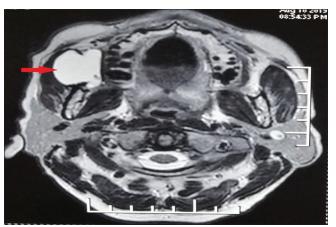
Imaging axial magnetic resonance imaging (T1-weighted imaging): A well-circumscribed nonenhancing T1 hyperintense cystic lesion deep to the masseter muscle (arrow head)
